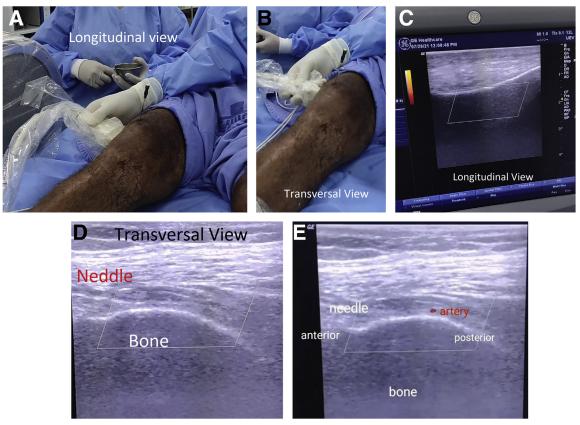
Ultrasonographic images of needle placement, of superolateral genicular nerve: ultrasonographic image control. (A) Ultrasound transducer aligned parallel to the femoral long axis; (B) ultrasound transducer aligned perpendicular to the femoral long axis; (C) ultrasound image corresponding to (A); (D) ultrasound image corresponding to (B); and (E) Doppler view of the genicular artery near the needle tip.
